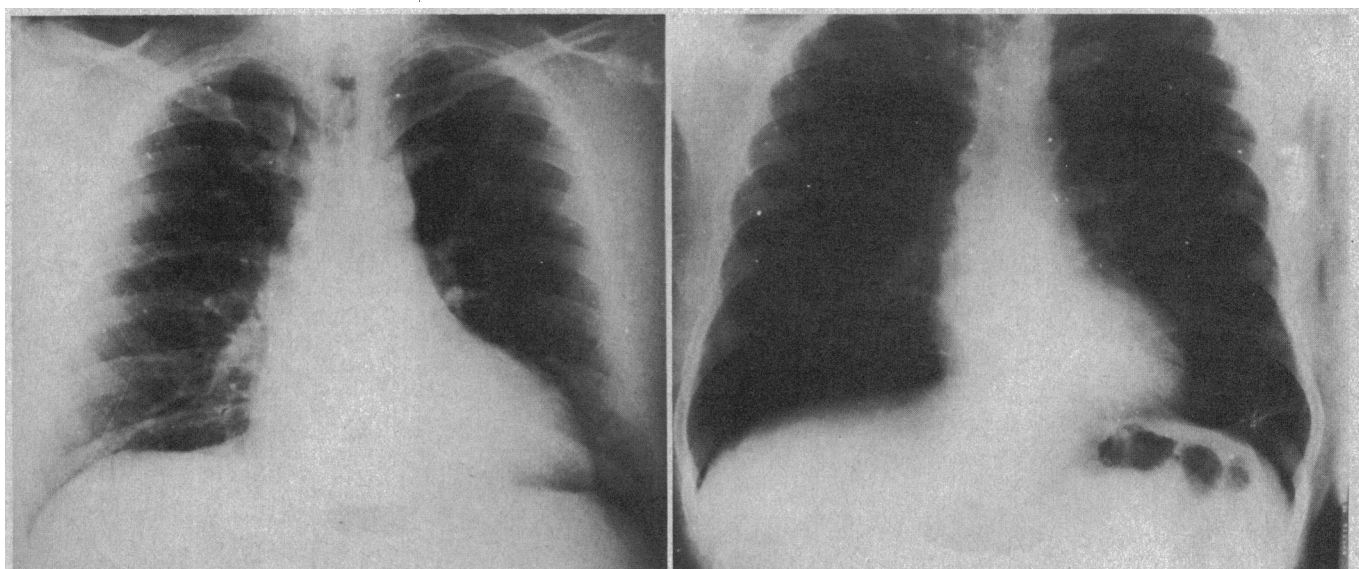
Chest x-ray films of patient 3 (see Fig 2) showing improvement in heart-chest ratio from 0.524 to 0.431. Left, Initially on Nov 7, 1972, transverse diameter of heart was 19.9 cm and internal chest diameter, 38.0 cm. Right, After loss of 60.0 kg, on March 26, 1973, transverse diameter was 15.5 cm and internal chest diameter, 36.4 cm.
